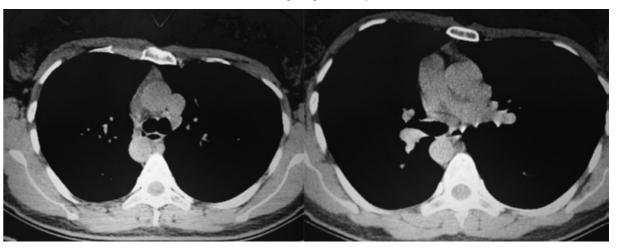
Axial CT scan slice of situs inversus with right-side aortic arch, pulmonary trunk and descending aorta.
